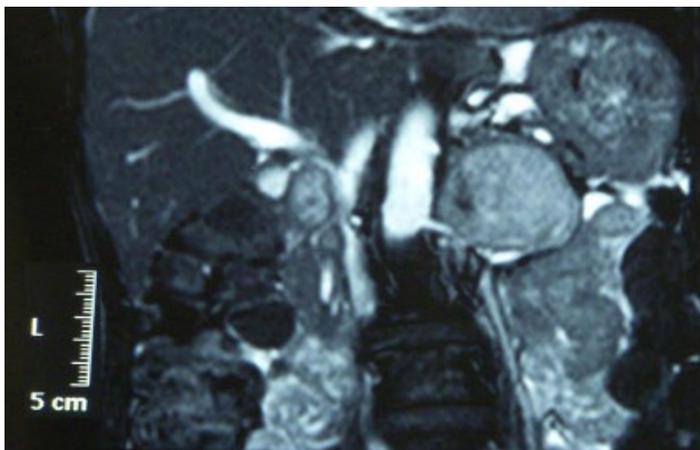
MRI on coronal section demonstrated left RAS caused by tumor compression
